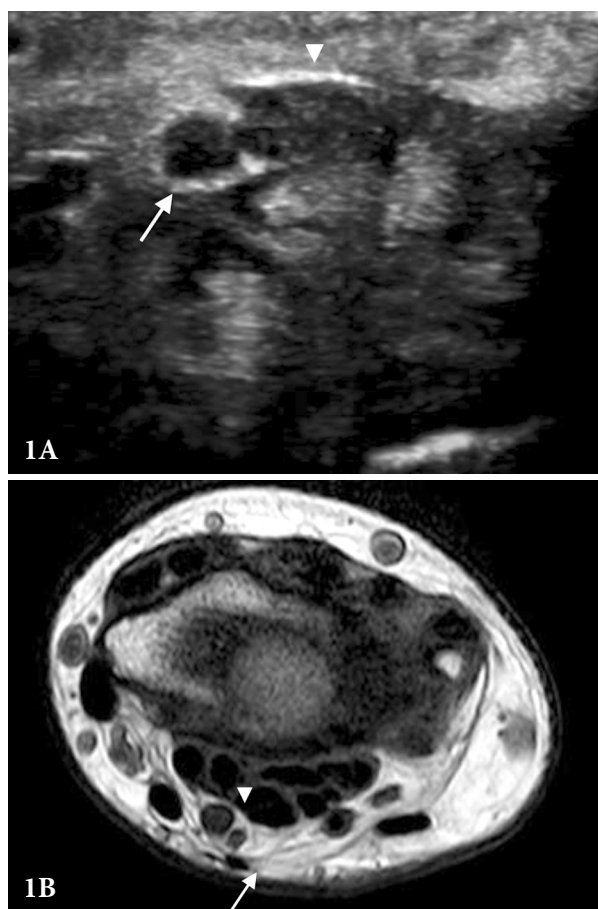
Ultrasound and magnetic resonance of the “incomplete” bifid median nerve in the left-hand area. Asymptomatic external branch of the bifid median nerve, with the cross-sectional area of 6 mm² (represented by the arrow); symptomatic internal branch, with the cross-sectional area of 15 mm² (represented by the arrowhead).
